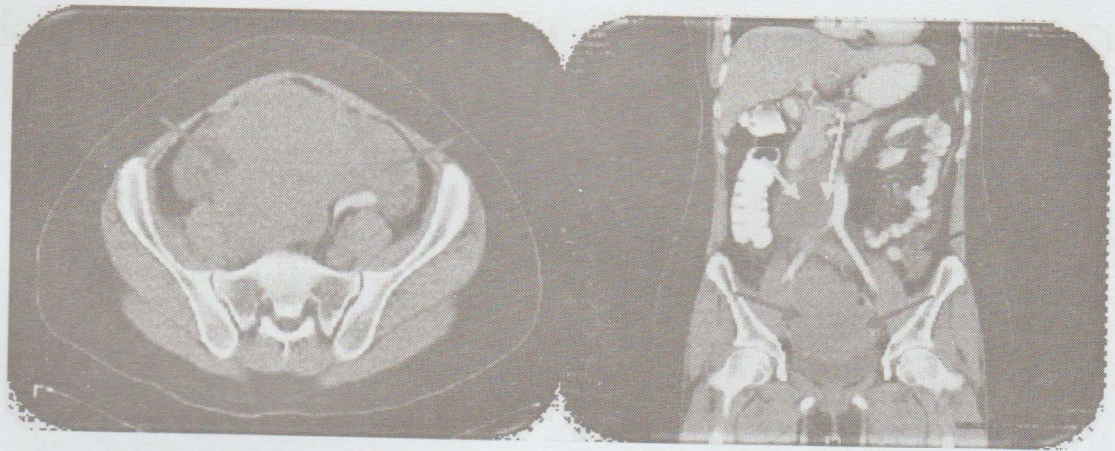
CT scan of the whole abdomen.
